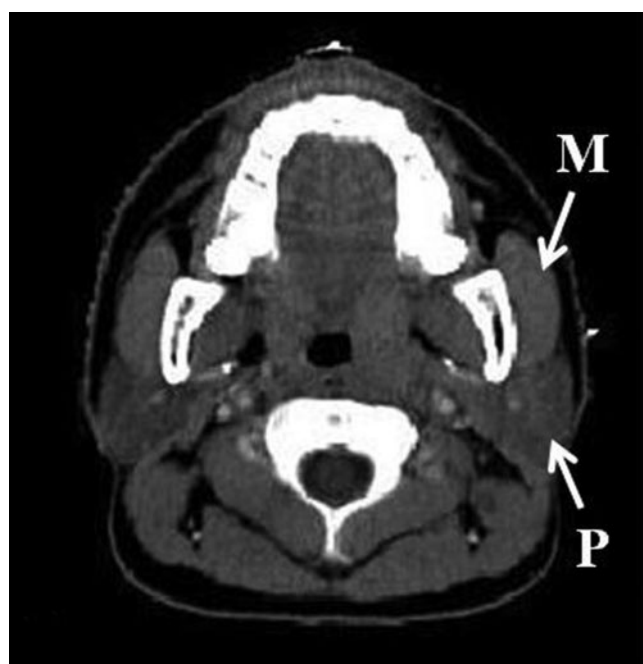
(a) Axial CT scan of skull in a nasopharyngeal carcinoma patient before radiotherapy. The image density of the parotid gland (P) is about the same as the adjacent masseter muscle (M). (b) Axial CT scan of a skull in the same patient after radiotherapy. There is an increased image density of the parotid gland (P) when compared with the pre-radiotherapy scan. The image density of the parotid gland is greater than that of the adjacent masseter muscle (M).
